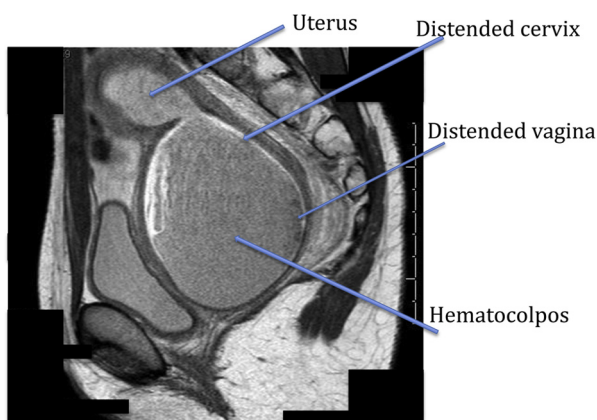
Pelvic MRI showing hematocolpos with distention of vagina and cervix.
